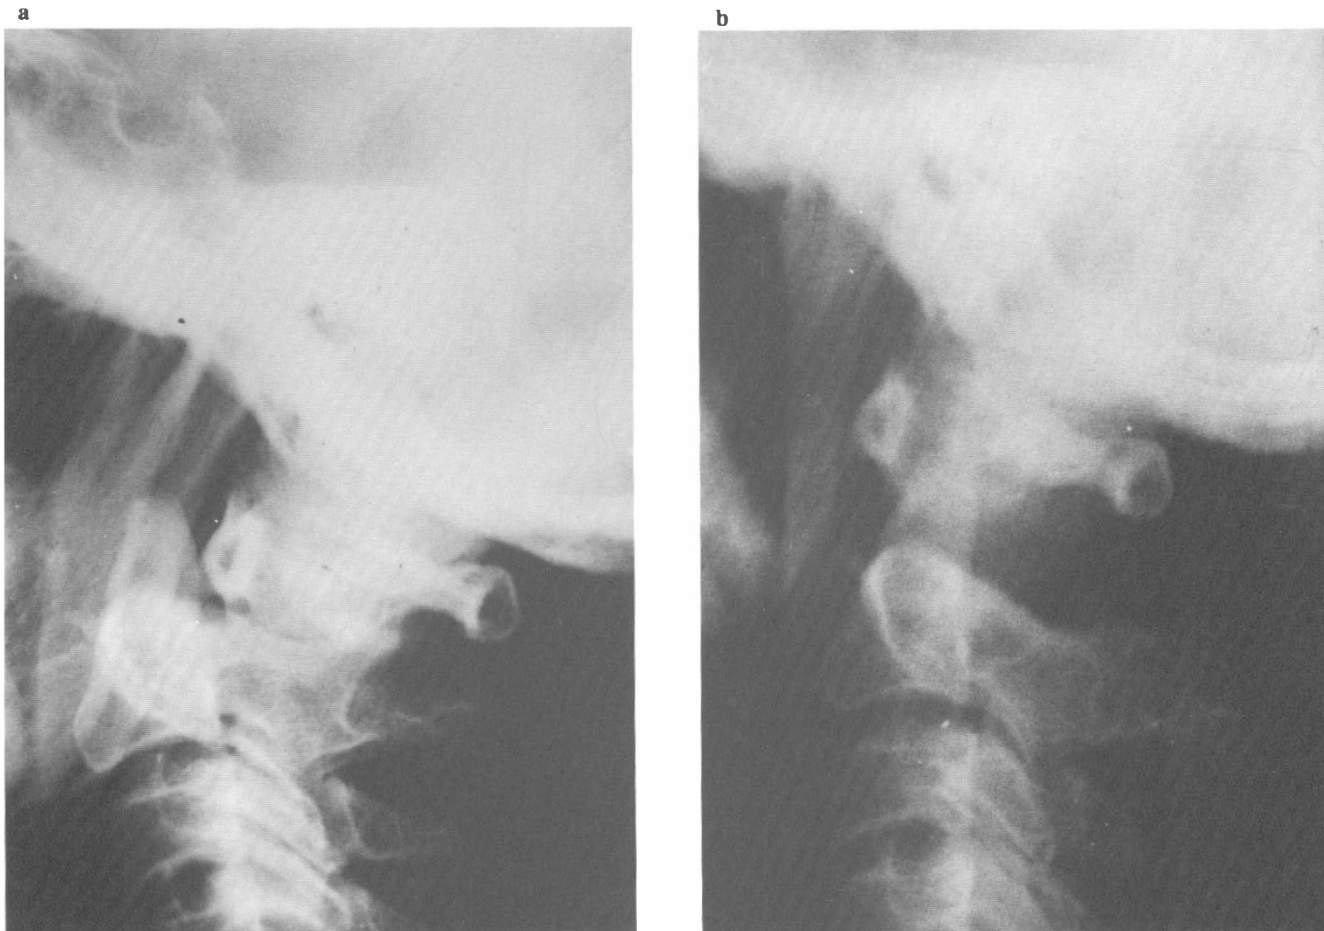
Upper cervical spine injury with short term survival. (a) This 5-year-old girl had a complete quadriplegia with severe respiratory distress. The lateral roentgenogram showed a dislocation of the atlanto-occipital articulation. Despite immediate intubation and control of general condition, she died 2 h after the injury. (b) This 25-year-old man had a complete quadriplegia with respiratory distress. The lateral roentgenogram showed a dislocation of C2-3. Despite immediate intubation, reduction of the dislocation using skull traction and control of general condition, he died 54 h after the injury
